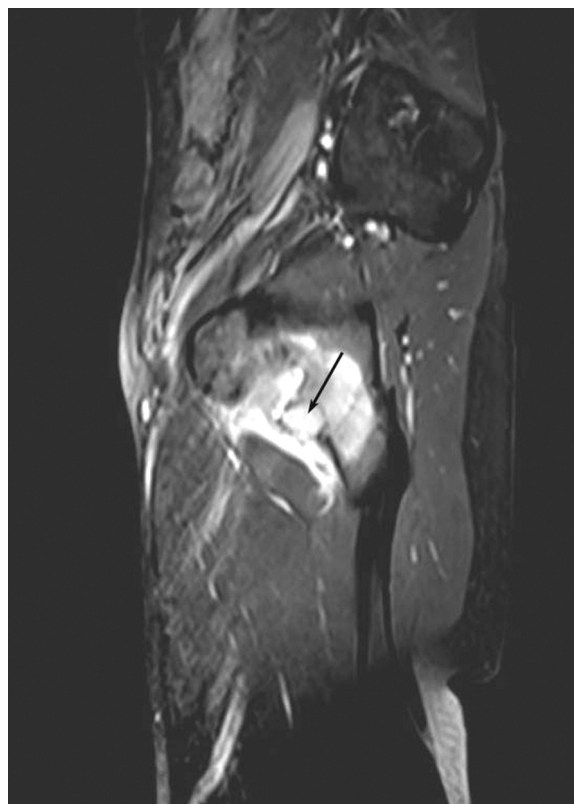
Sagittal fat-suppressed T1-weighted image after the administration of contrast medium shows an intense enhancement of the tumor and the adjacent muscle and bone marrow. (arrow).
